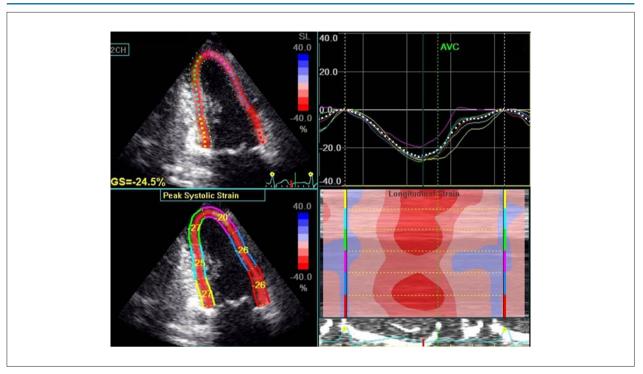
Example of global longitudinal strain analysis using speckle tracking echocardiography. GS: global longitudinal strain; AVC: aortic valve closure.
